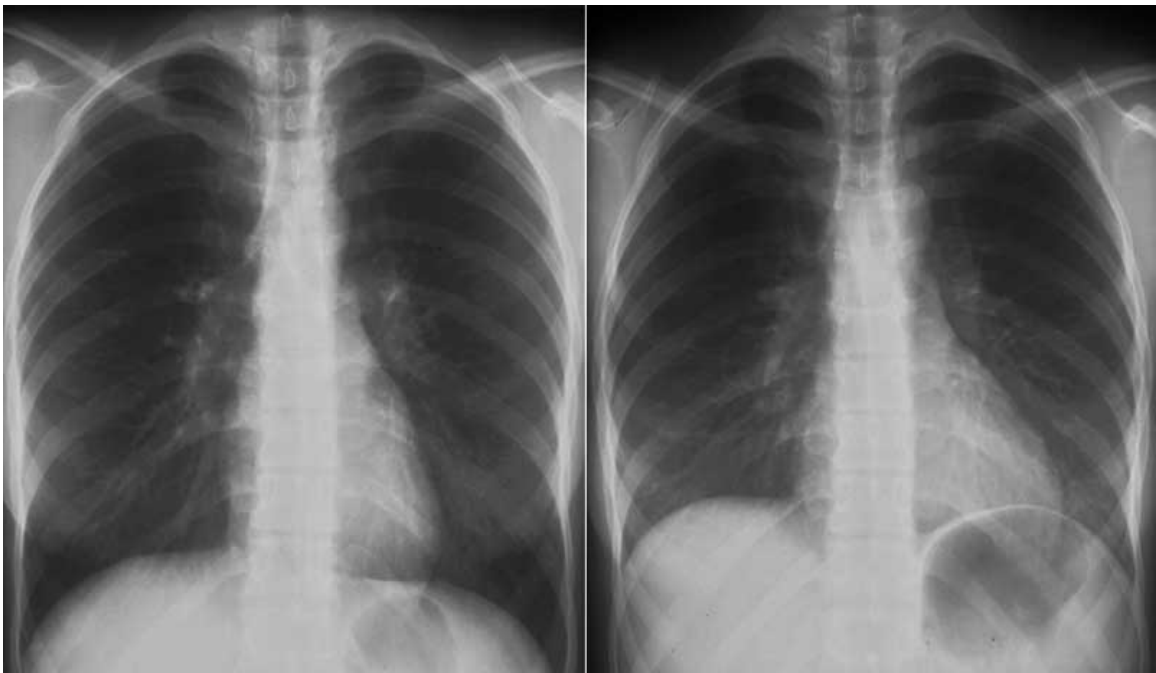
Chest x-ray image with normal (*left*) and enlarged (*right*) heart
